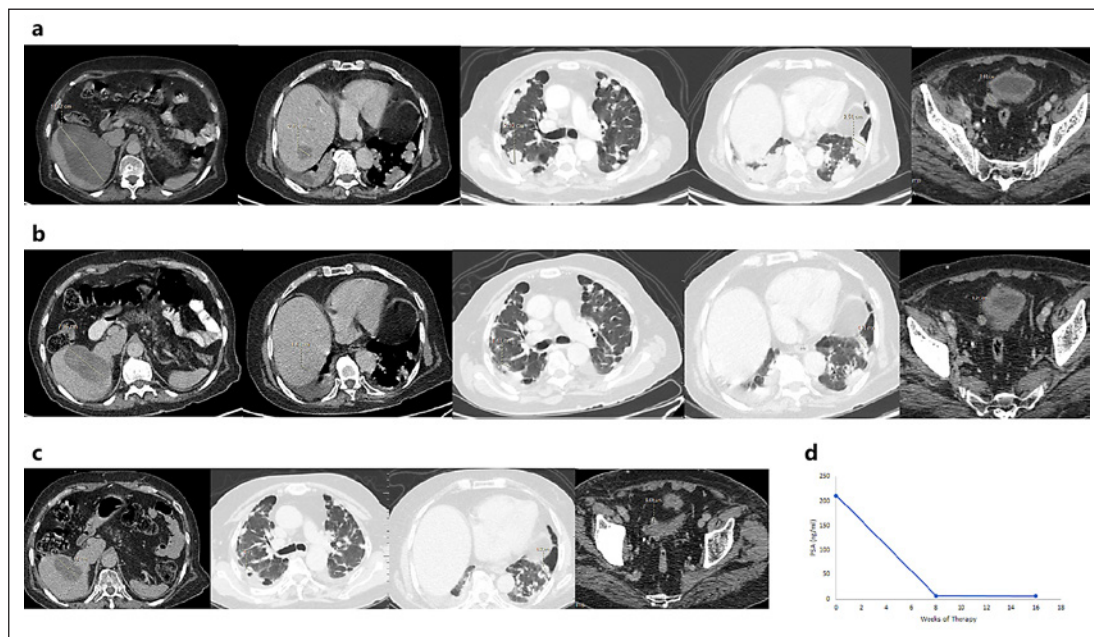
a Baseline PSMA PET-CT images. b PSMA PET-CT images after 2 cycles of olaparib and carboplatin therapy. c PSMA PET-CT images after 4 cycles of olaparib and carboplatin therapy. d PSA level at baseline and after 8 and 16 weeks of therapy. PSMA PET-CT, prostate-specific membrane antigen positron emission tomography computed tomography; PSA, prostate-specific antigen.
